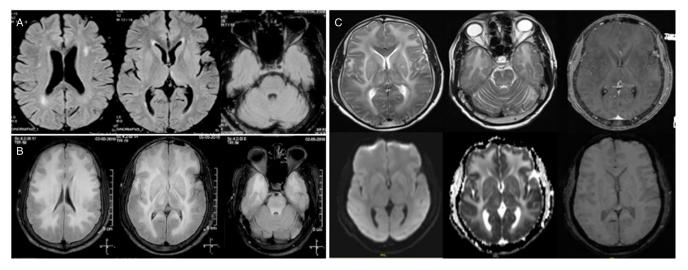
Sequential MR images of the patient. α : FLAIR axial images of initial MRI (June 2015) showed nonspecific discrete subcortical and deep periventricular frontoparietal white matter hyperintensities. b: MRI at second presentation (May 2018) revealed diffuse cerebral edema with extensive, symmetric white matter hyperintensities involving U fibers, anterior temporal lobes, external capsules, basal ganglia, brainstem, and cerebellar hemispheres (not shown). c: MRI at our institution (June 2018) revealed persistence of symmetric expansile, white matter hyperintensities with no enhancement. There was no evidence of diffusion restriction or blooming (lower row).
